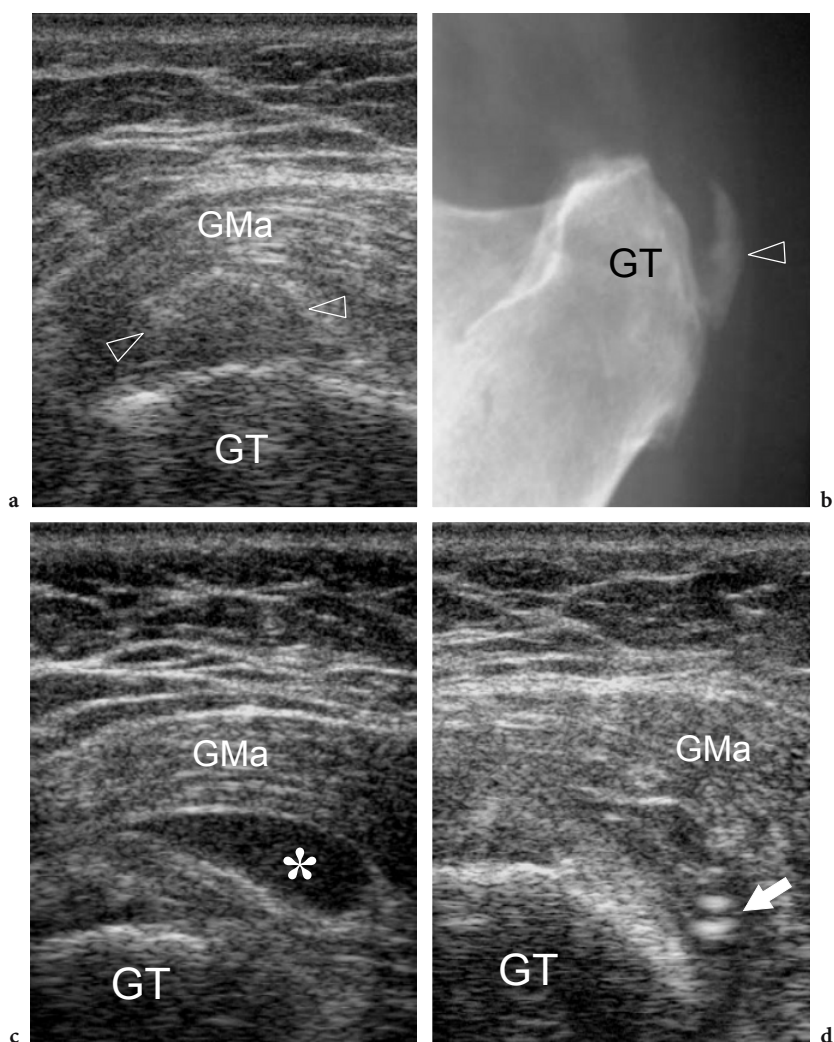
Trochanteric bursitis. a Transverse 12–5 MHz US image obtained over the greater trochanter (GT) shows an irregular calcification (*arrowheads*) with faint posterior acoustic shadowing located within the gluteus medius tendon and deep to the gluteus maximus muscle (GMa). b Anteroposterior radiograph confirms the occurrence of an arc-shaped calcification (*arrowhead*) over the greater trochanter (GT). c Transverse 12–5 MHz US image obtained in a more posterior position relative to a demonstrates distension of the trochanteric bursa by anechoic fluid (*asterisk*). d Same scanning plane shown in c during US-guided injection of corticosteroid. Note the reverberations of the needle tip (*arrow*) positioned at the center of the bursa under US guidance.
